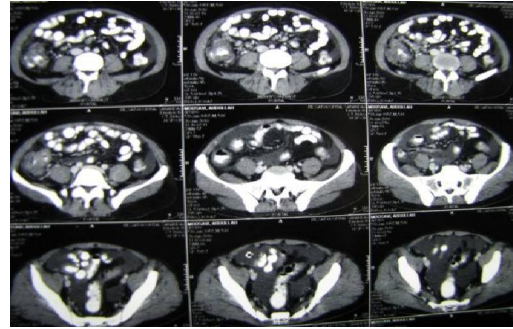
Abdomen computed tomography (CT) without the application of contrast revealed thickening of the of cecum and terminal ileum.
